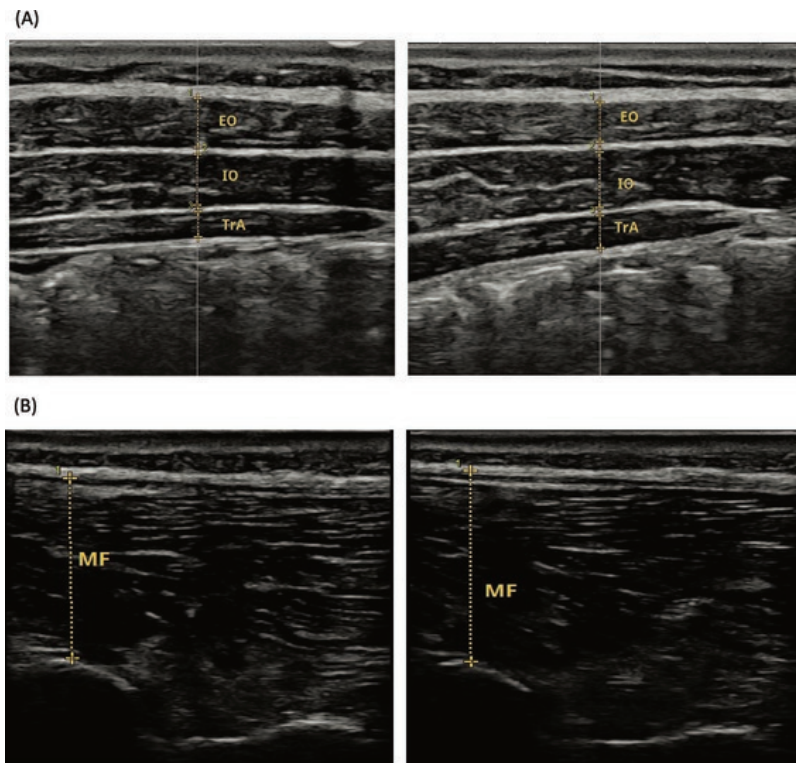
Ultrasound imaging measurement of the thickness changes for the external oblique (EO), internal oblique (IO), and transverse abdominis (TrA) muscles (A) and the multifidus (MF) muscle (B) between the resting (left images) and activation (right images) conditions.
